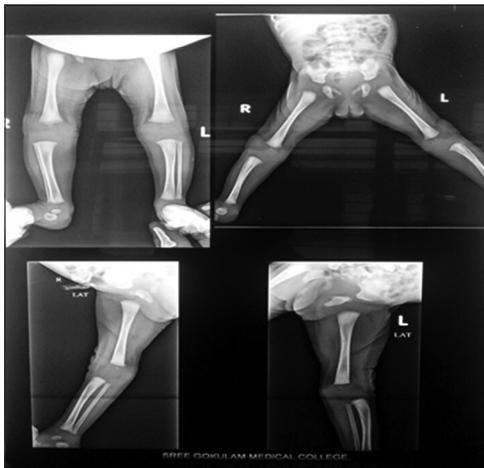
Radiograph of the lower limbs including the knee joint showing dislocation
